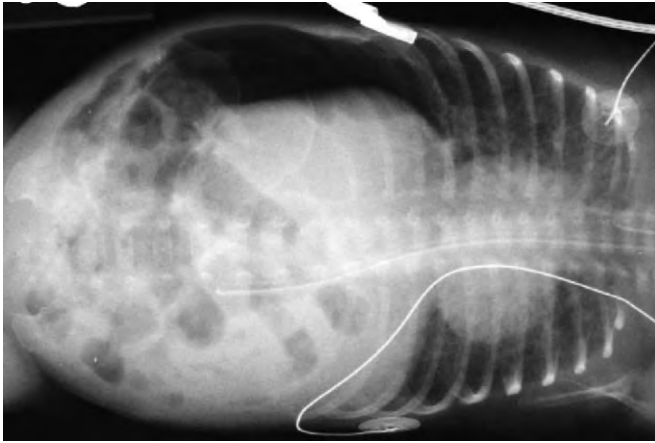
Pneumoperitoneum in necrotizing enterocolitis. An abdominal radiograph in the left lateral decubitus position demonstrates a large amount of free intraperitoneal air and extensive intestinal pneumatosis. (Courtesy of A. B. Campbell, MD, St. Christopher's Hospital for Children.)
